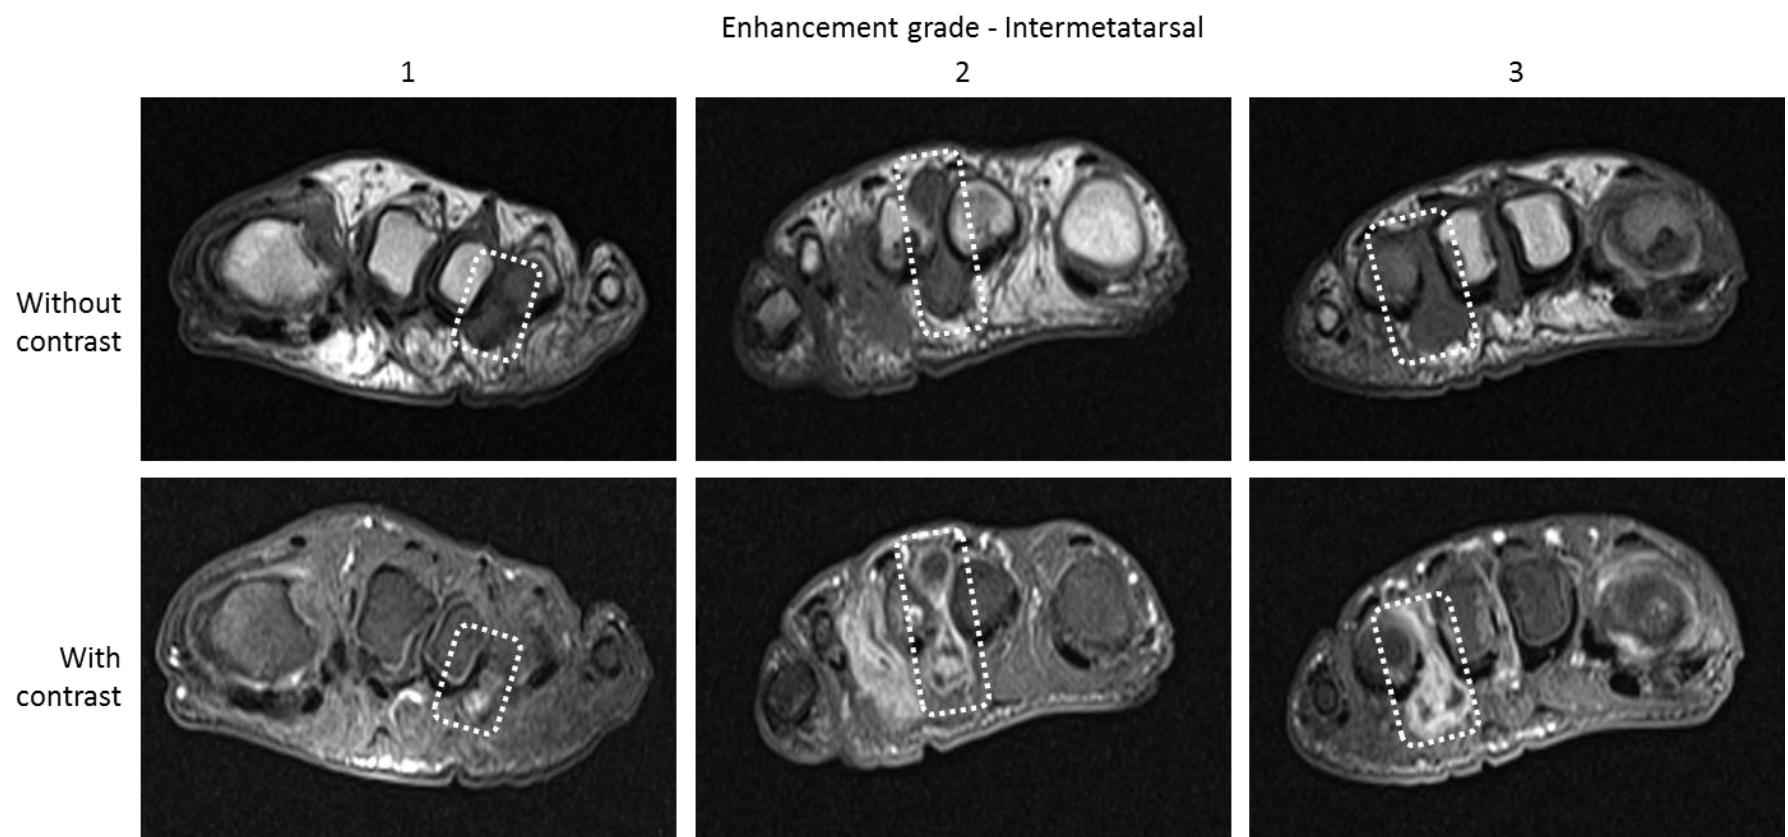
Differences in MRI-detectable FFB enhancement: intermetatarsal lesions
